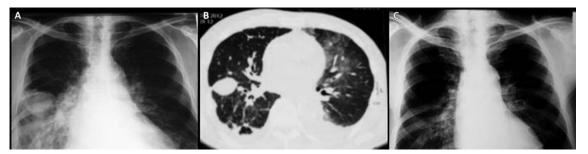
A. PA chest radiography showed sharply marginated opacity in the right middle fissure; B. CT described dense rounded silhouette in right mid zone 4,5cm in diameter; C. normal chest X ray after intensive diurtetic therapy
